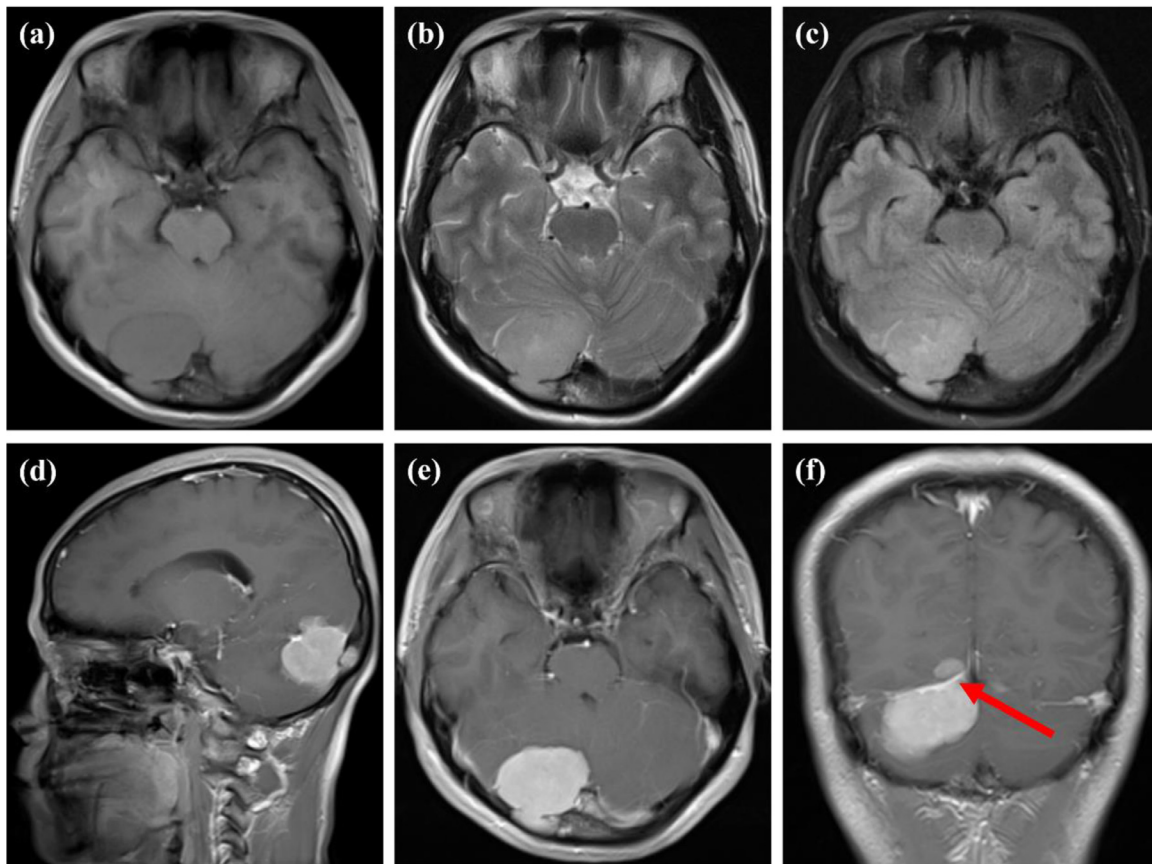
MRI showed that there was a solid mass in the right occipital cerebellar tentorium. The lesion showed isointense on T1WI and slightly hyperintense on T2WI, and relatively homogenous on FLAIR, respectively (a-c). The mass exhibited homogeneous enhancement, with the dural tail sign (arrow) (d-f).
